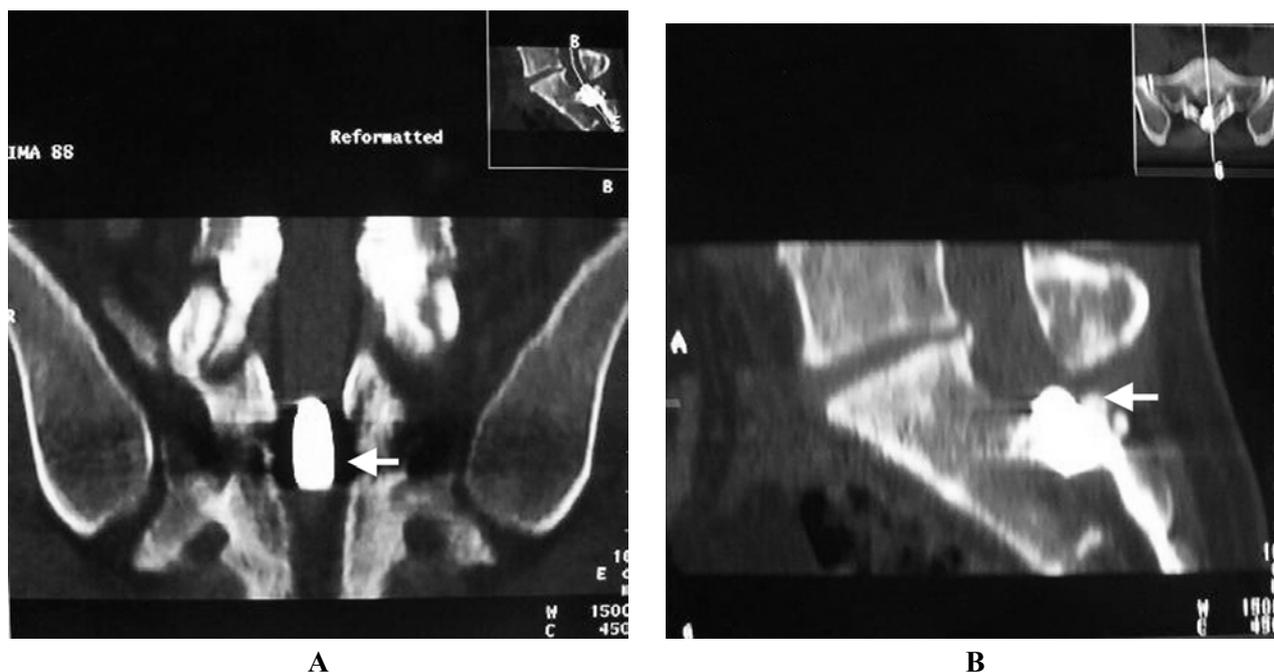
A–B – CT scans revealed retained bullet in the spinal canal at the level of the second sacral vertebra (arrows)
